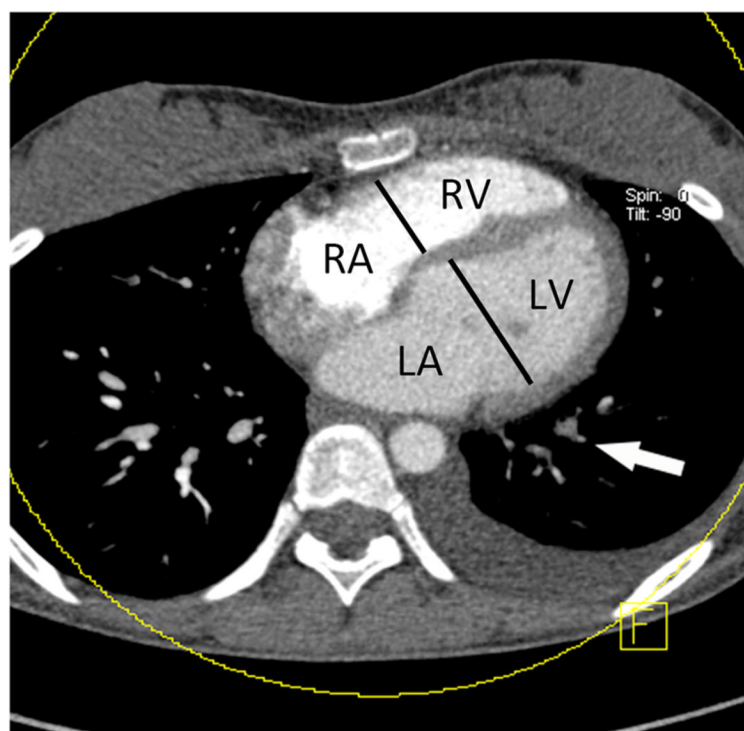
Maximal diameter measurement of the right and left ventricles in axial contrast-enhanced CT image in a 15-year-old girl with podocytopathy. Measurements should be performed at the levels of right and left atrioventricular valve. Note the filling defects in the left inferior pulmonary arteries (*arrow*). *RA* right atrium, *LA* left atrium, *RV* right ventricle, *LV* left ventricle
